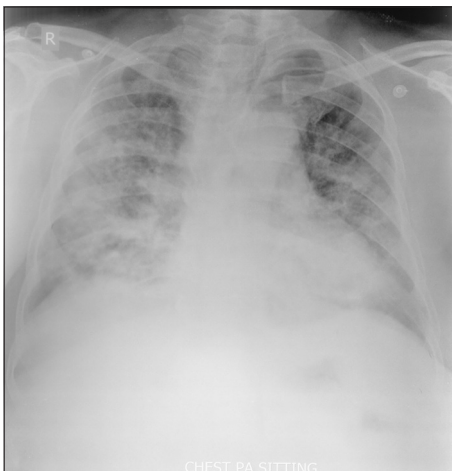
Chest radiograph of the patient two at admission
